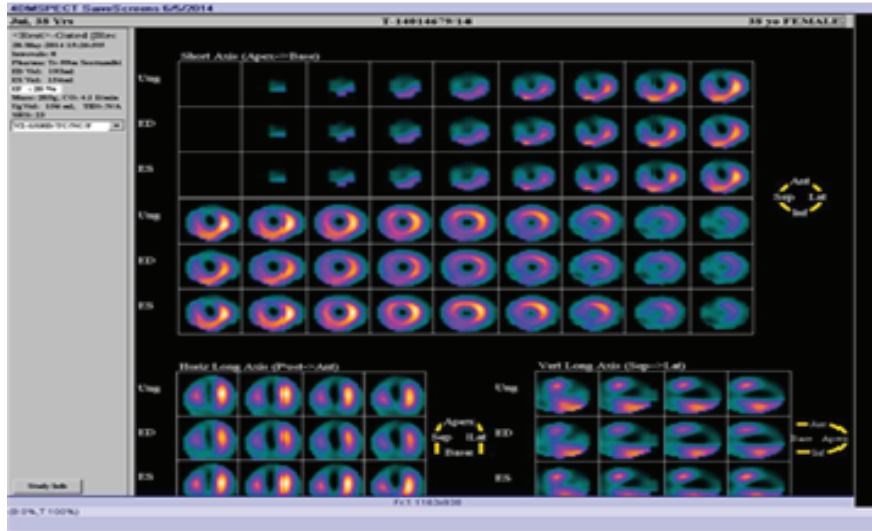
Gated SPECT Myocardial Perfusion Imaging image of a 38 years old female patient shows the dilatation of left ventricular cavity by large EDV=193 ml, large ESV= 154 ml and lower EF= 20% , antero-apical and septal ischemia, all parameters diagnosed her as a Dilated Cardiomyopathy patient.
